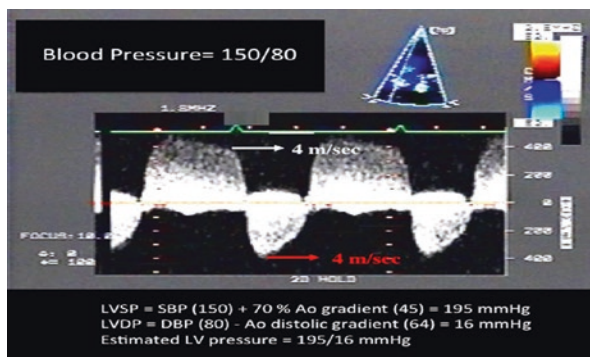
Continuous wave Doppler (CW) in the calculation of left ventricular (LV) pressures in a patient with aortic stenosis and insufficiency (see text). Aortic stenosis peak velocity (*red arrow*) and aortic regurgitation end-diastolic velocity (*white arrow*) both measure to be 4 m/s. Other abbreviations: *Ao* Aorta, *LVSP* Left ventricular systolic pressure, *LVDP* Left ventricular diastolic pressure, *SBP* Systolic blood pressure, *DBP* Diastolic blood pressure
